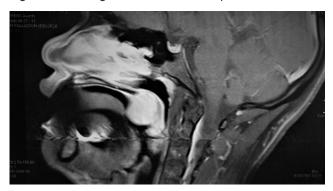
Magnetic resonance imaging showing the lesion in the retro pharyngeal area, impairing the superior airways.
